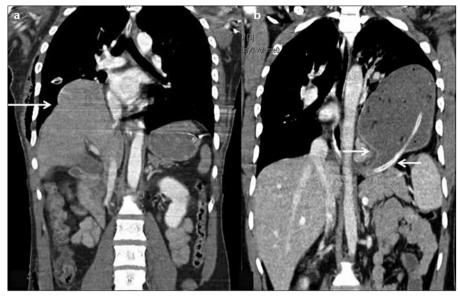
a, b. Coronal reformatted CT image (a) shows a rounded portion of the liver herniating through the diaphragm, forming a hump-shaped mass (*arrow*), which is suggestive of the collar sign on the right. The coronal reformatted CT image of another patient (b) displays intrathoracic herniation of the stomach through a defect in the left hemidiaphragm, with a focal constriction of the stomach at the site of herniation (*arrows*), which depicts the collar sign on the left.
